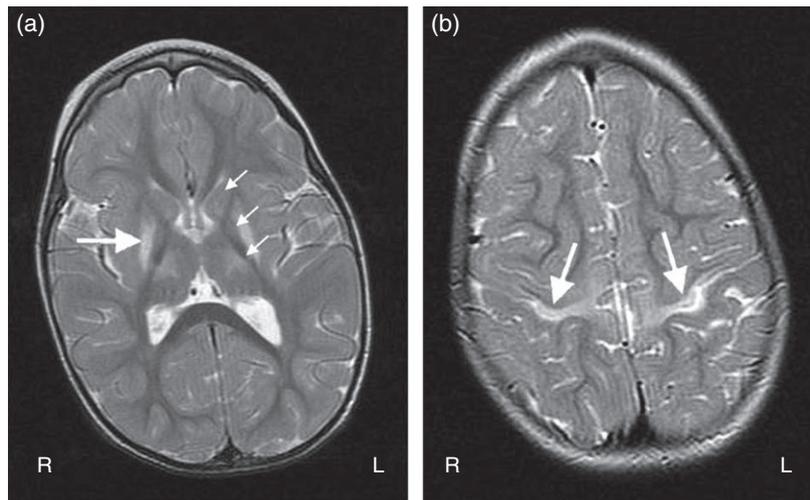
Moderate grey matter injury. Brain MRI in a 24-month-old male with history of meconium aspiration. (a) Axial T2-weighted image demonstrates bilateral, symmetric gliotic changes in the basal ganglia, including the putamen and globus pallidus minimally (small arrows) and thalami (long arrow). (b) Similar changes along the central sulcus bilaterally.
